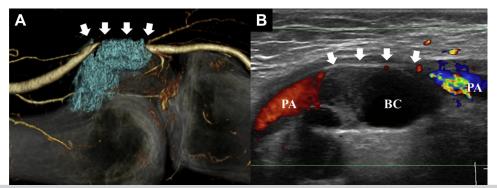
A, Computed tomography angiography image showing focal narrowing of the popliteal artery (*arrows*) at the right knee. The Baker cyst appears polycystic (*blue masses*) and attached to the popliteal artery. B, Color Doppler ultrasound image demonstrating flow disturbance in the popliteal artery (*PA*) by the Baker cyst (*BC*).
